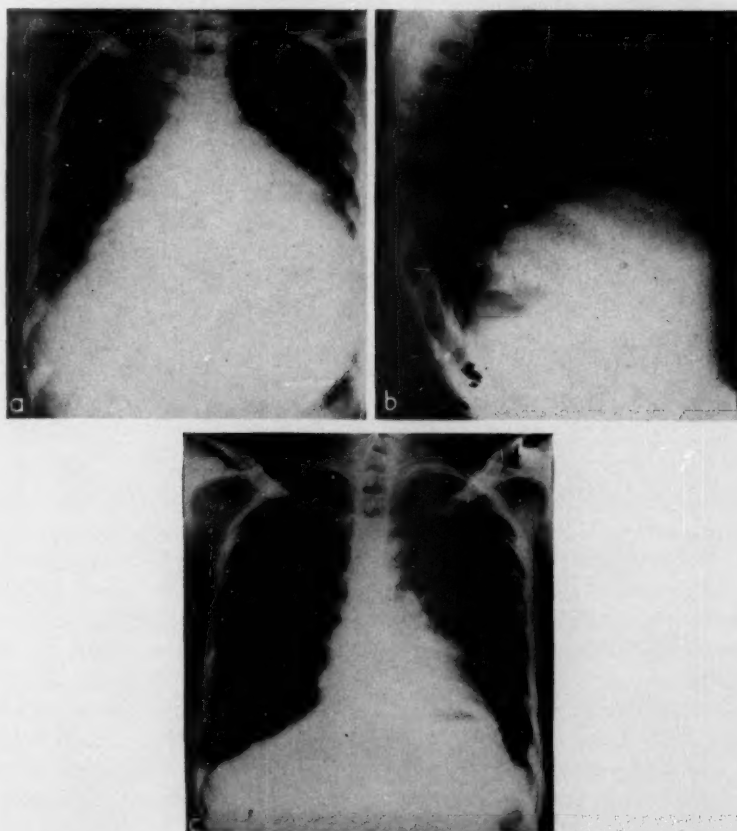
Case 2. (a) Postero-anterior radiograph showing 'sympathetic' pericardial effusion. (b) Lateral radiograph eight days later, after 1,500 ml. of pus had been aspirated from the liver abscess cavity and air instilled. The level of the diaphragm is shown by the air-fluid level. (c) Postero-anterior radiograph of the same patient 18 days after (a), showing marked reduction in size of the cardiac shadow. An air-fluid level is still present in the liver
